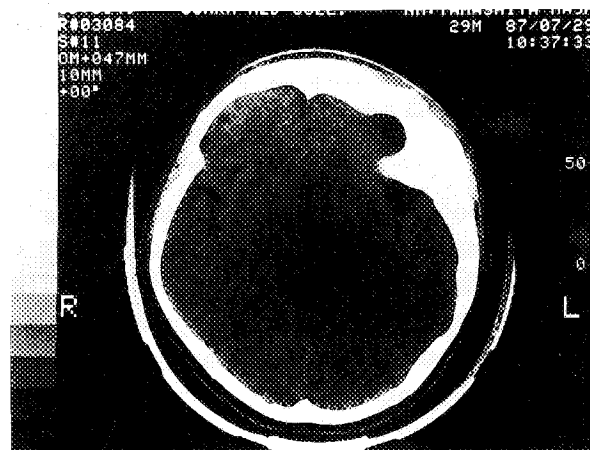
Computed tomographic scan of Patient 1. Bony thickening is noted in the frontal region.
